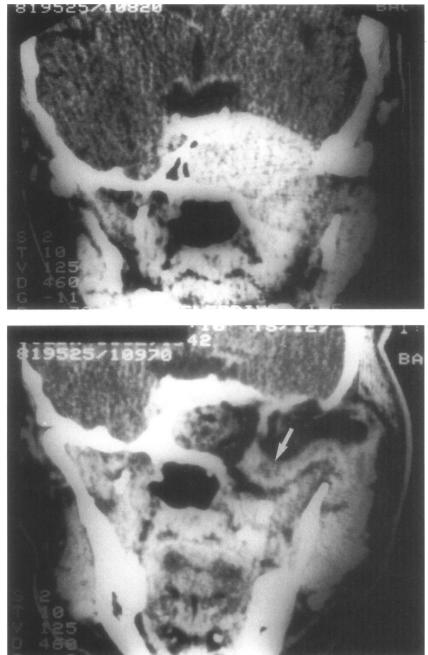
Infratemporal fossa paraganglioma on the left side (case 4). A. Preoperative coronal CT showing elevation of middle cranial fossa dura and invasion of sphenoid sinus. B. Postoperative (10 days) coronal CT showing radical tumor removal (infratemporal fossa approach type C) and temporalis muscle flap placed within the operative cavity (\rightarrow).
